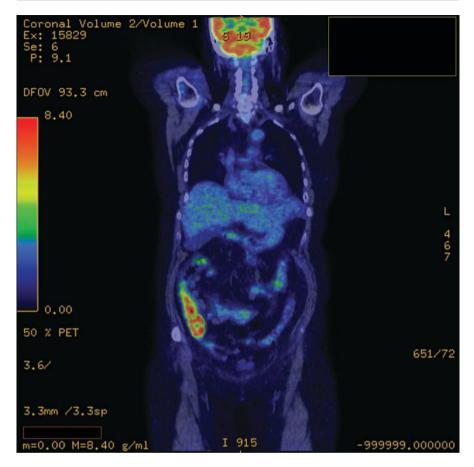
PET CT of the Skull to Thigh demonstrating areas of moderate fluorodeoxyglucose (FDG) activity in the colon of a patient with a suspected malignancy. Resection of the colon revealed a marked lymphohistiocytic inflammatory infiltrate predominantly involving the subserosa and mesentery with associated fibrosis and small-vessel vasculitis (arteritis and phlebitis). No evidence of malignancy was found
